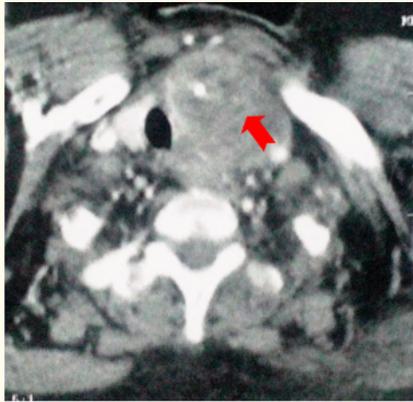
CT scan axial section: a locally advanced left thyroid tumor infiltrating the trachea, the larynx and the adjacent muscles.
